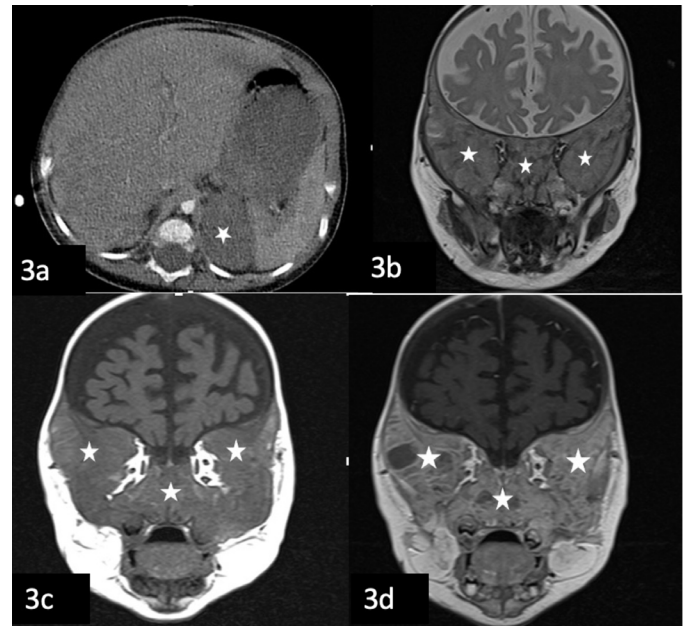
(A) Axial CT imaging shows smoothly contoured hypodense mass lesion in left surrenal gland localization. Coronal T2W (B) hyperintense, coronal T1W (C) hypointense and postcontrast images (D) show extensive metastatic bone lesions in the frontal bone, sphenoid bone, filling the nasal cavity, showing heterogeneous contrast enhancement
